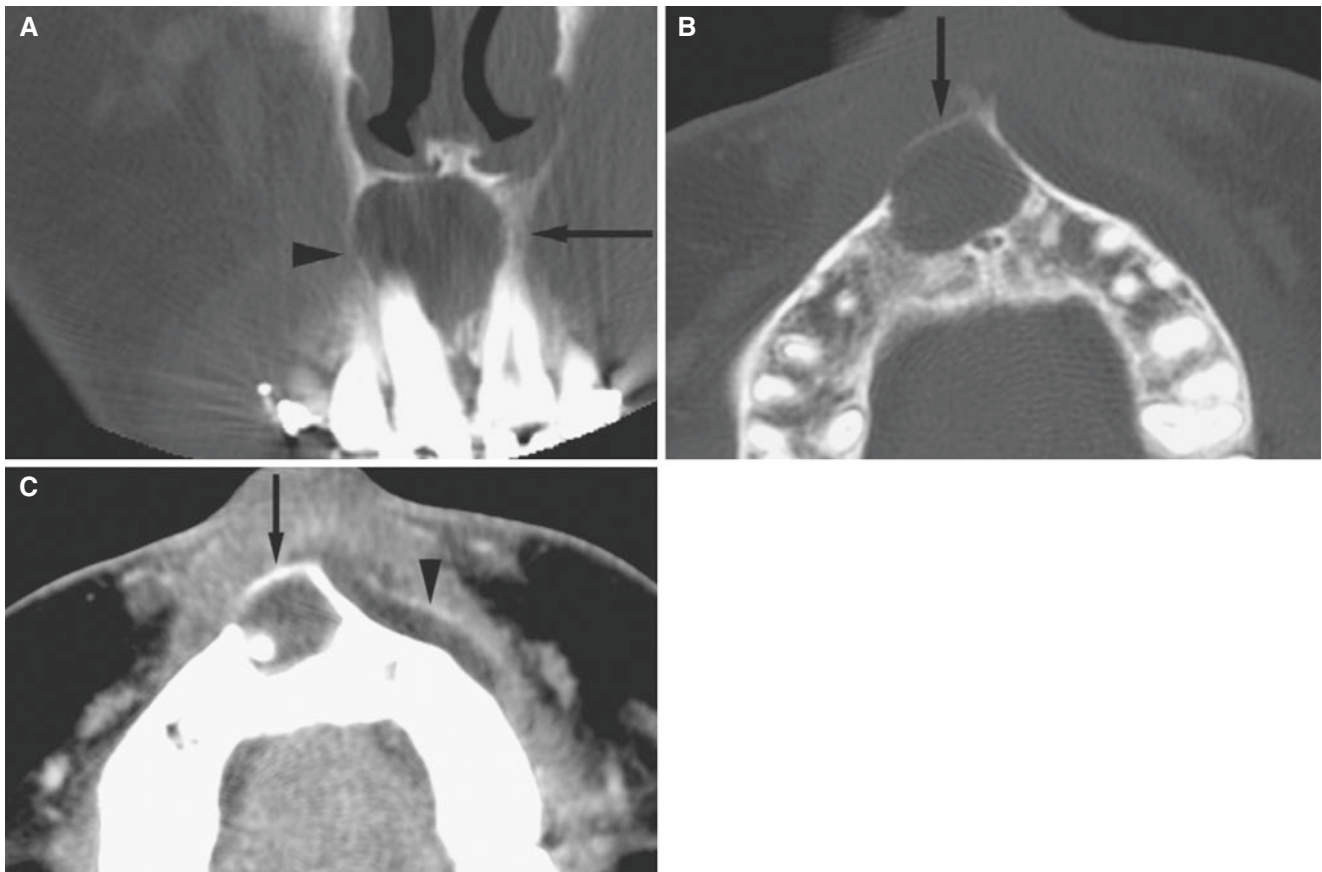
Periapical cyst, maxilla, with abscess development; 14-year-old male with swelling of mucobuccal fold, pain, foul odor, and nonvital right central incisor. (A) Coronal CT image shows expansive process with well-defined border (*arrow*), thin and perforated on right side (*arrowhead*). (B) Axial CT image shows process (*arrow*) with no sclerotic
